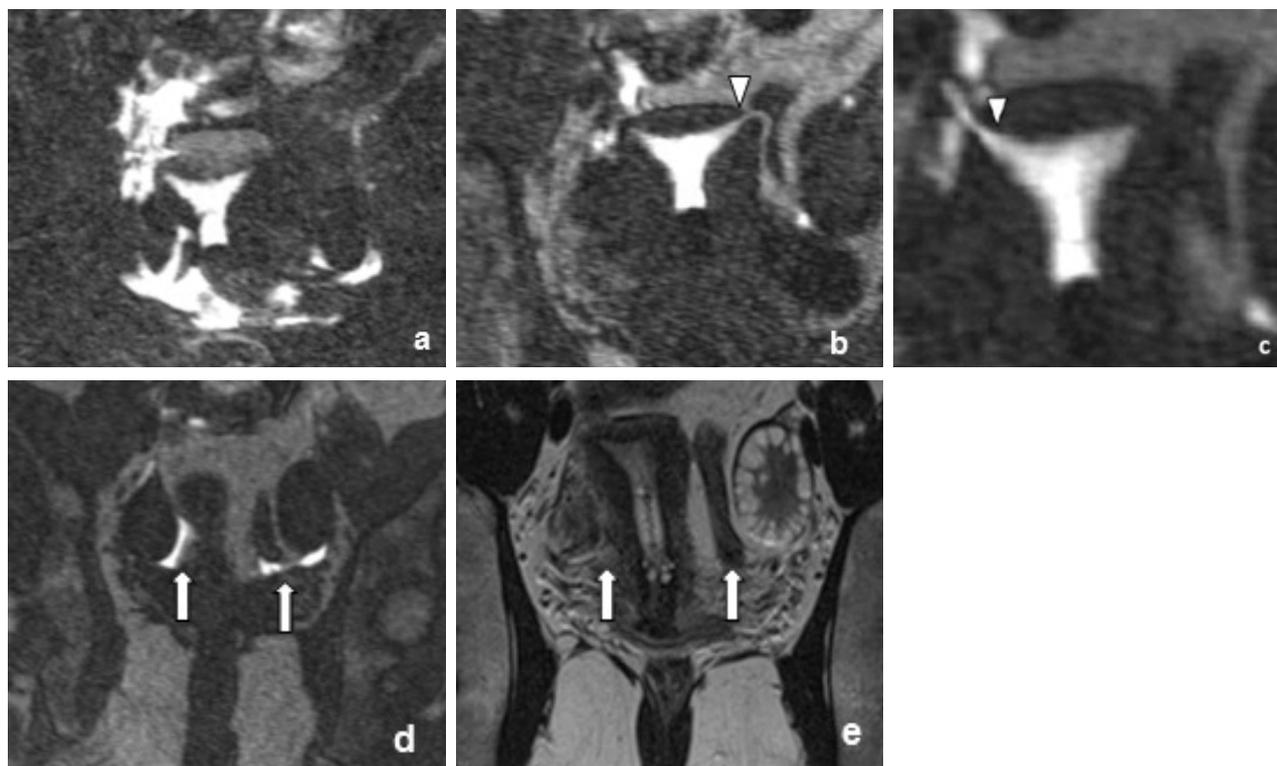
FLASH 3D DYN T1-weighted images after intrauterine contrast injection (MIP). Accumulation of contrast solution in the uterine cavity appears regular and there is initial filling of the intramural portion of the tubes with bilateral and simultaneous spillage of contrast medium into the peritoneal cavity: bilateral tubal patency (a). Initial non subtracted FLASH 3D DYN T1-weighted images from series of 7 sequences after intrauterine contrast injection reveal the ampullary portion of the left tube (arrowhead) (b) and the intramural portion of the right tube (arrowhead) (c). Comparative analysis of final non subtracted FLASH 3D DYN T1-weighted images from the same series (d) and baseline T2-weighted TRUE FISP (e) shows the symmetrical spillage of contrast agent in the periovarian region on the left and in the periuterine region on the right (arrows).
